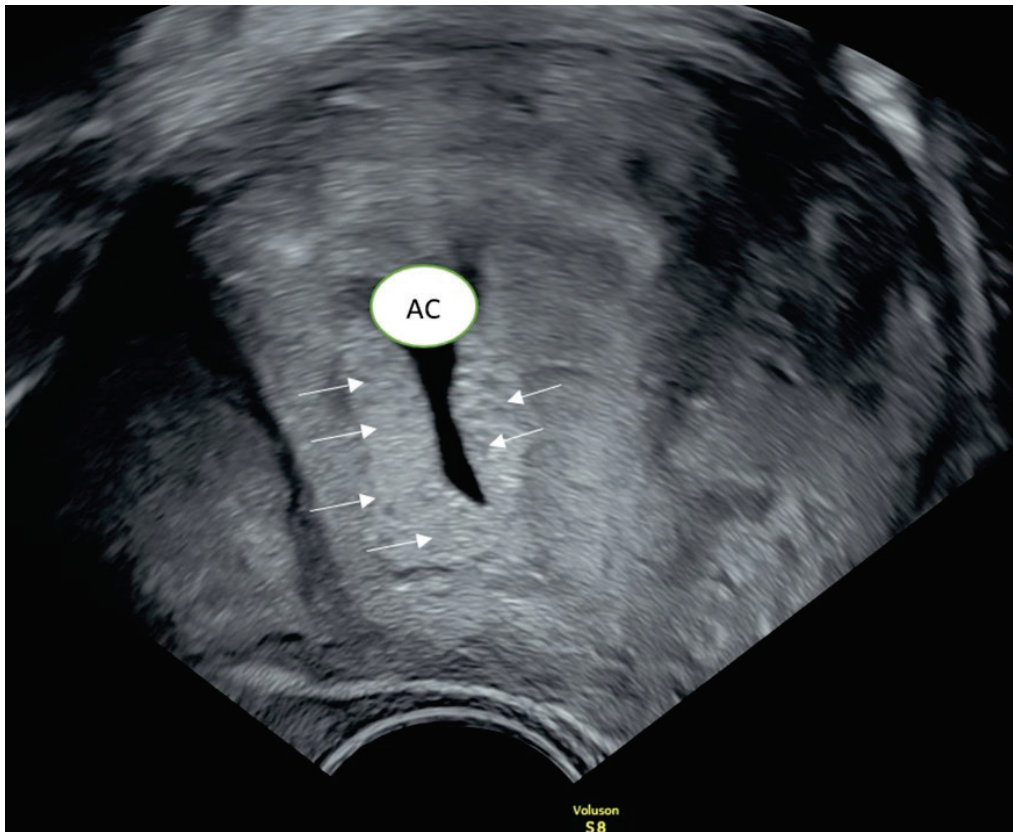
Transvaginal ultrasonographic picture of the second pregnancy loss (Voluson S8 GE, source: Centre for Gestational Trophoblastic Disease of Slovak Republic). AC - irregular amniotic cavity without embryonic structure, white arrows - multiple small cystic spaces inside the placenta ("molar placenta") - „swiss - cheese” appearance
